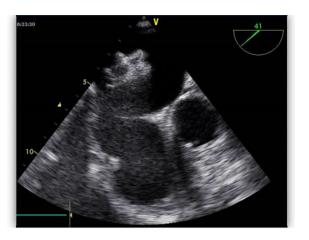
Device embolization. Intraprocedural transesophageal echocardiography: embolization of the device into the left atrium
